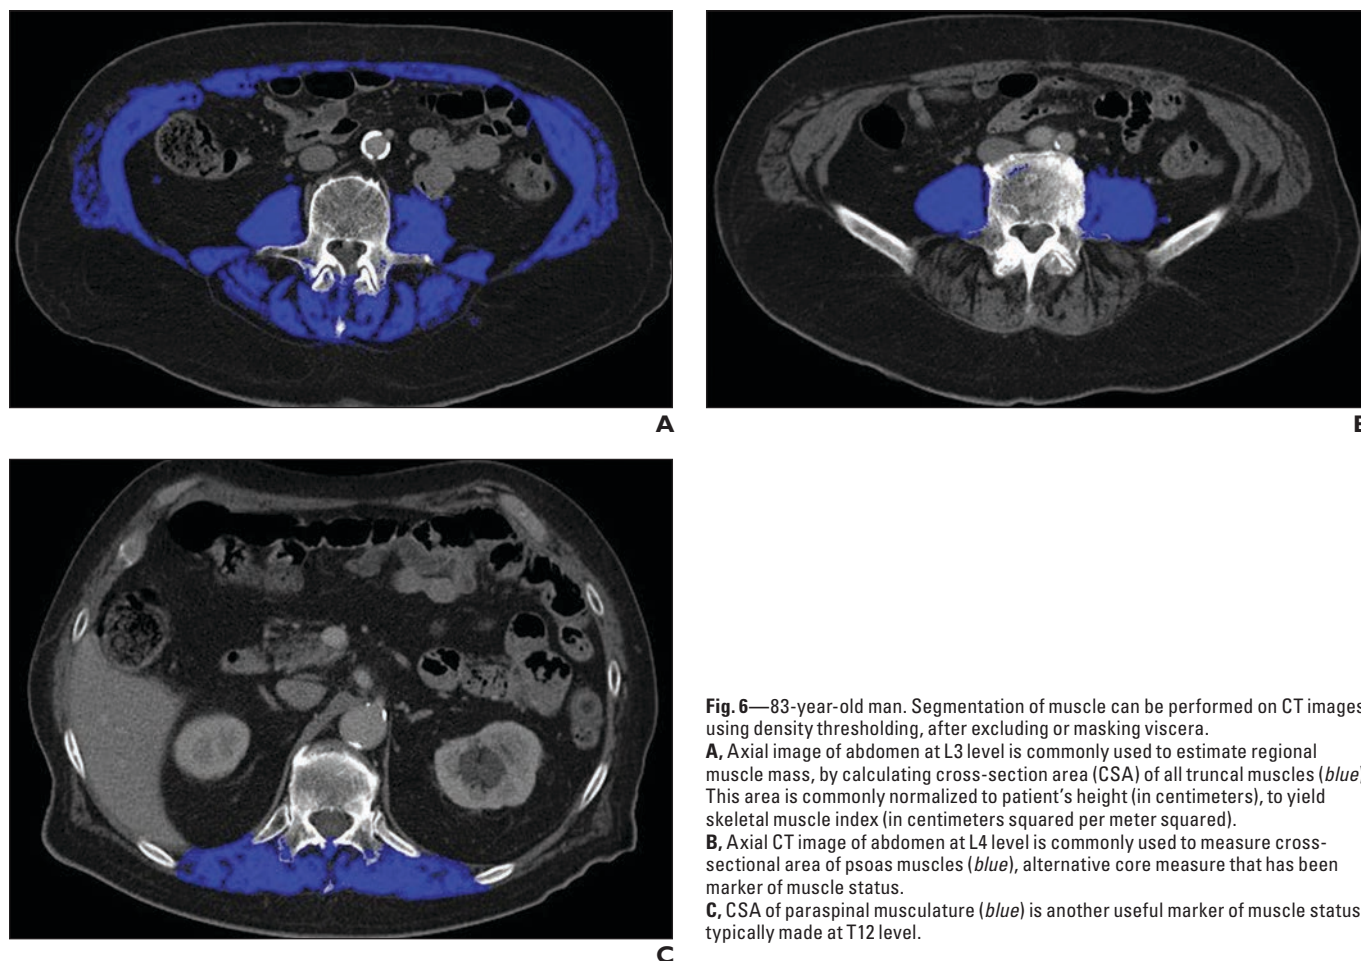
83-year-old man. Segmentation of muscle can be performed on CT images using density thresholding, after excluding or masking viscera.
